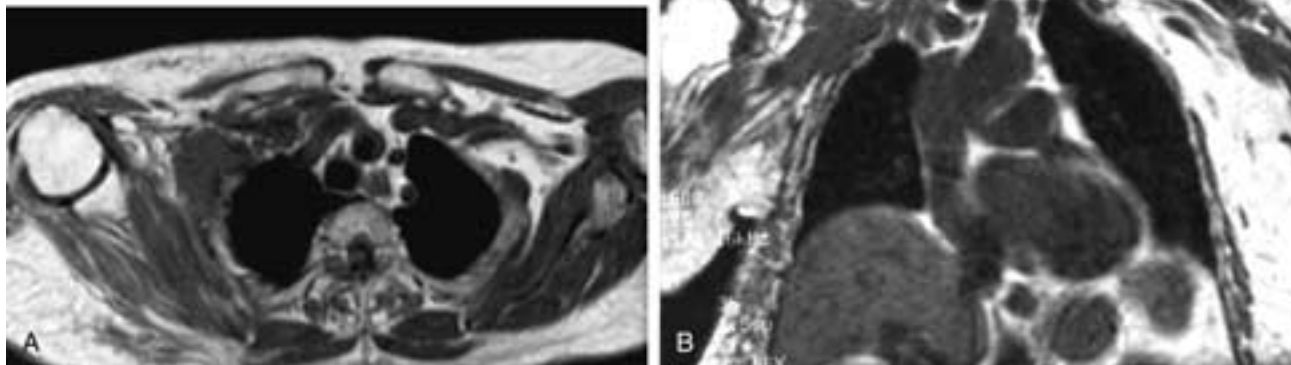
Metastatic breast carcinoma. Axial (A) and coronal (B) T1-weighted MR images show a mass in the right axilla that surrounds the axillary artery. Note the increased signal in the muscles of the right shoulder girdle. This is consistent with denervation atrophy.
